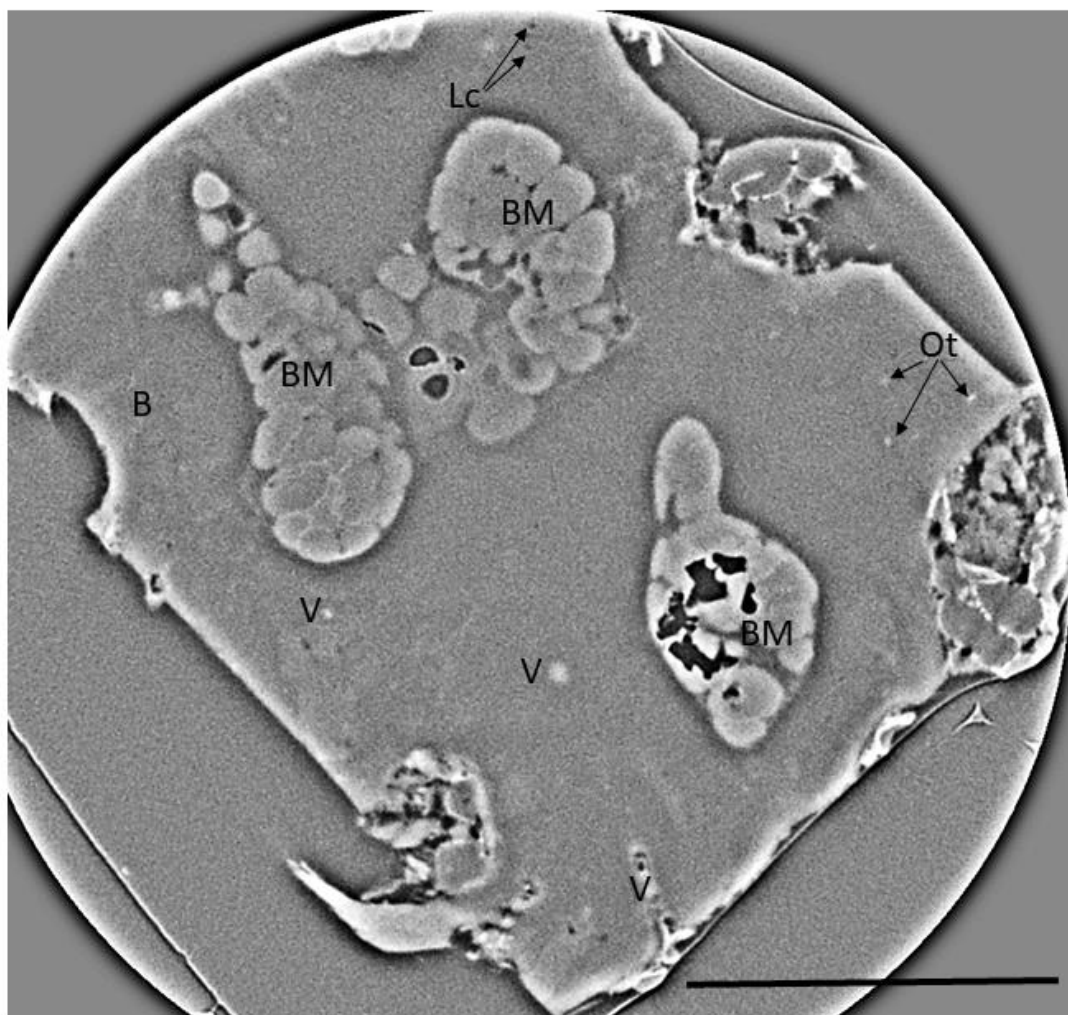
X-ray μ CT of human bone tissue
